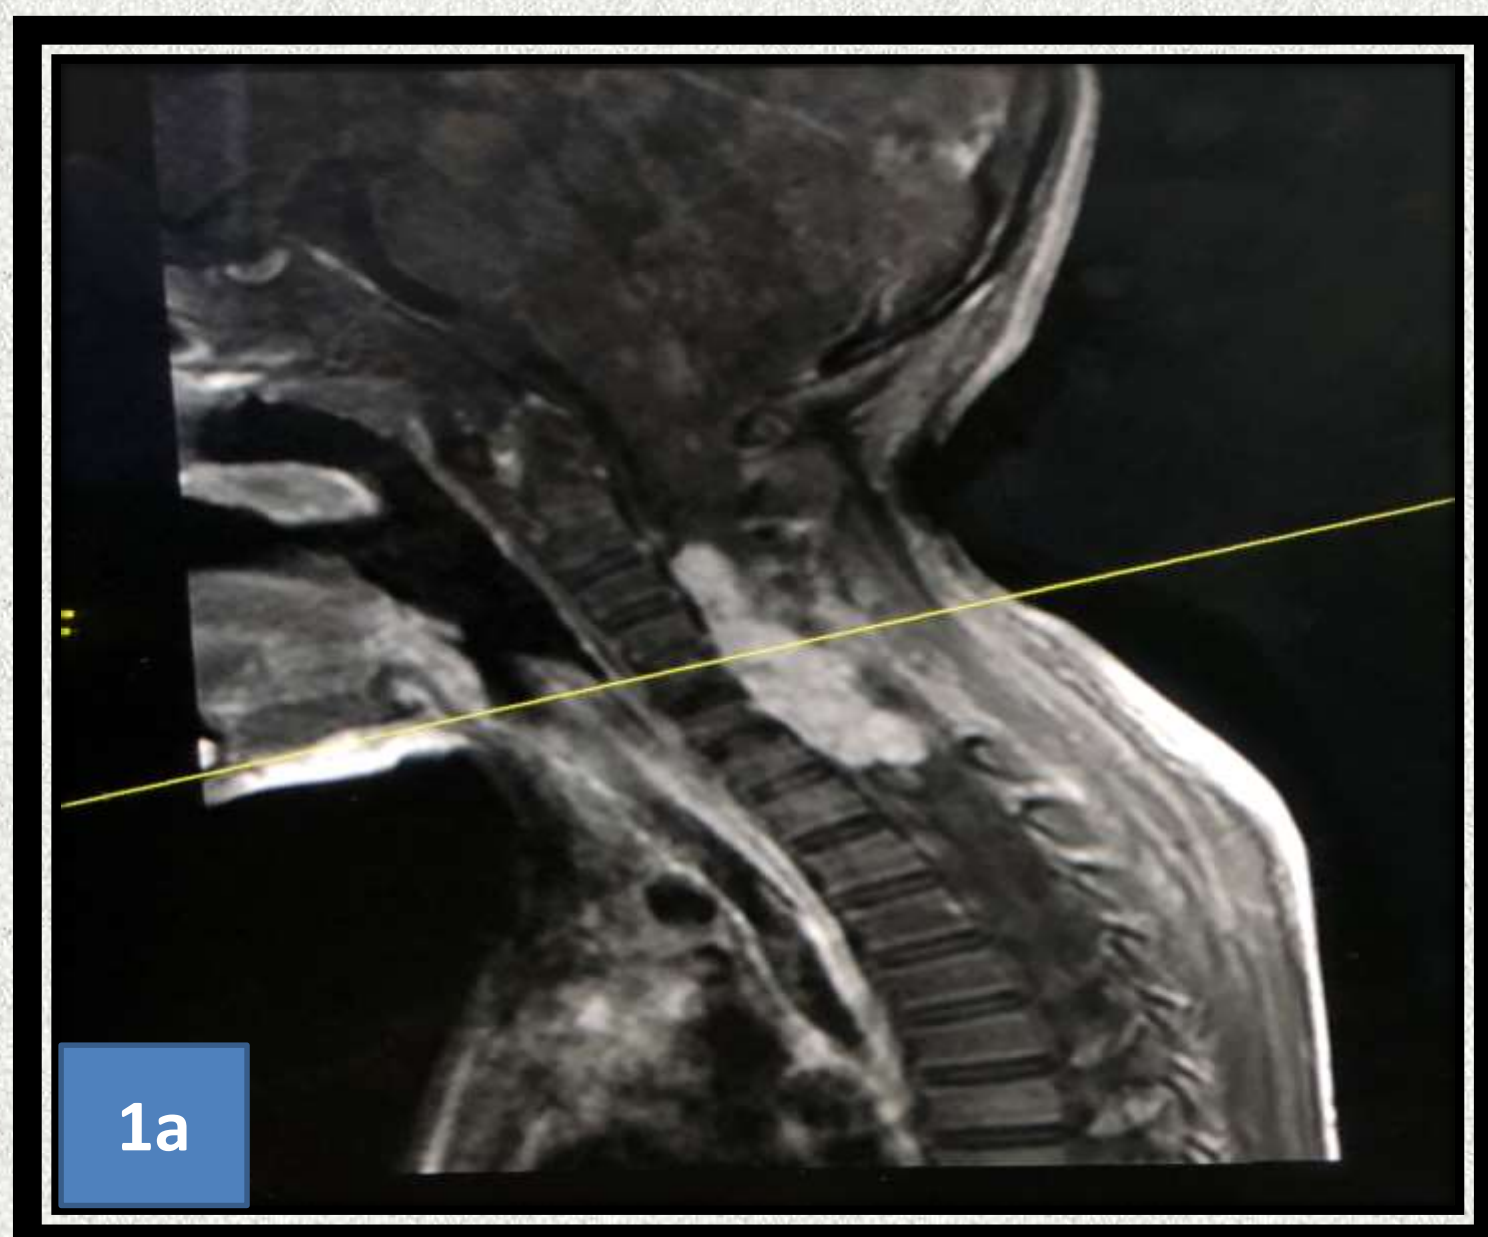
MRI show intradural extramedullary mass at the right cervical region from the level of C4 to the C8 which appear cystic, heterogeneously hypointense on T1 and hyperintense on T2 and features suggestive of benign peripheral nerve sheath tumor. Figure 1b: MRI show a large intermuscular capsulated mass at the right medial side of proximal arm causing splaying and compression of the surrounding muscle and this lesion appear solid with cystic component and reported as malignant schwannoma. (Source: USM PACS, GE Healthcare zero foot-print viewer)
